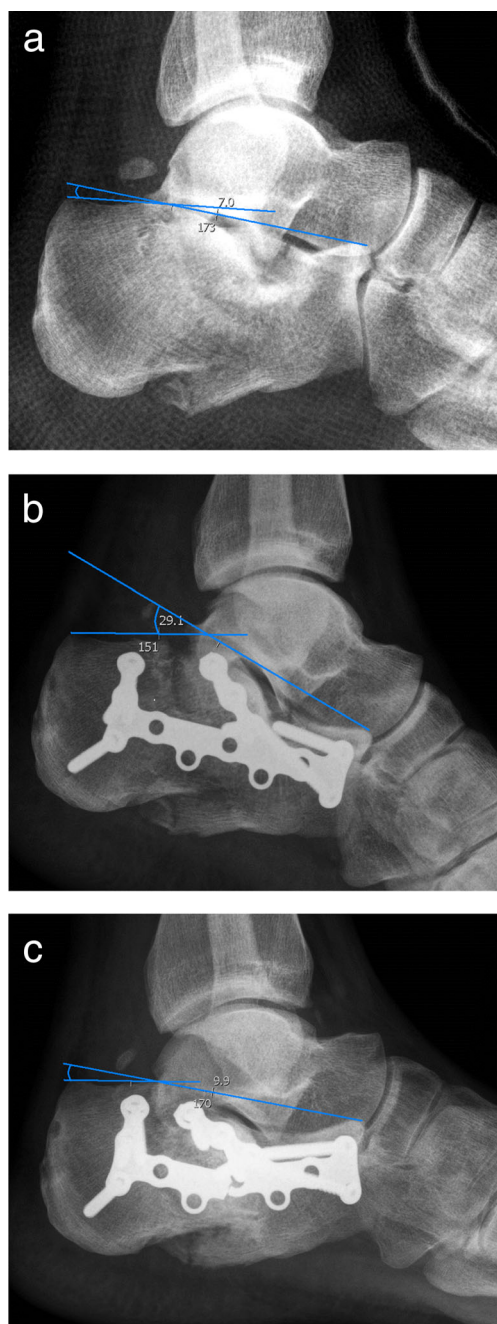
Böhler's angle (BA) is the angle formed by the intersection of an imaginary line joining the highest point of the anterior calcaneal process and the highest point of the posterior talocalcaneal joint, with a line drawn from the most superior point of the posterior talocalcaneal joint to the highest point of the calcaneal tuberosity, as measured on lateral foot radiograph. a Preoperative BA of 7°. b Post-operative BA of 29°. c Calcaneal collapse of 10° at one year follow-up
